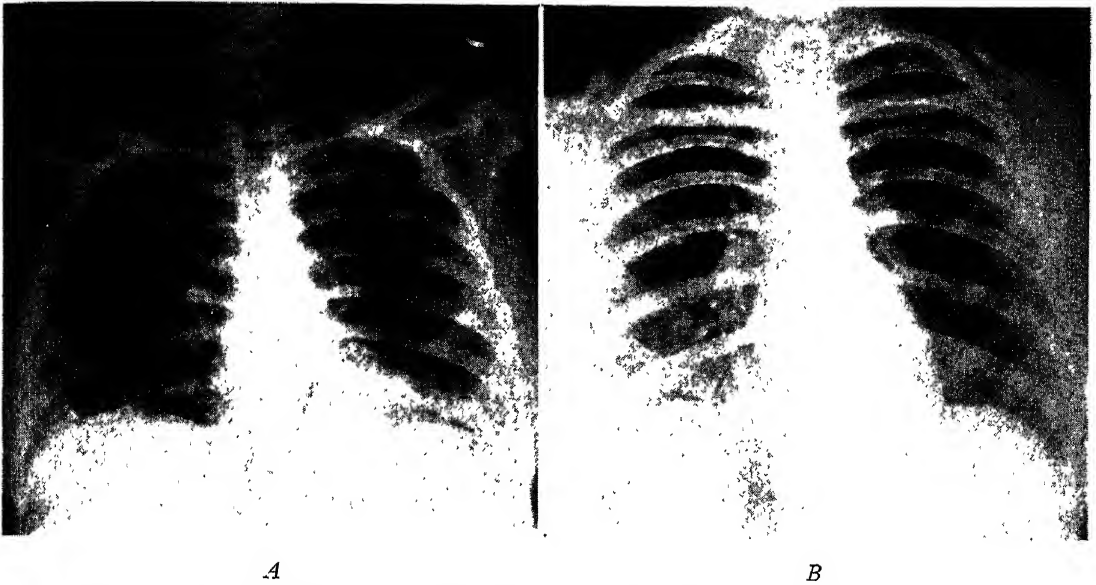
A*, Late "wire-grass" type infiltration (pseudofibrosis). *B*, Same case showing the lungs entirely clear in one week. (A. E. Seeds and M. L. Mazer: Am. J. Roentgenol.)
